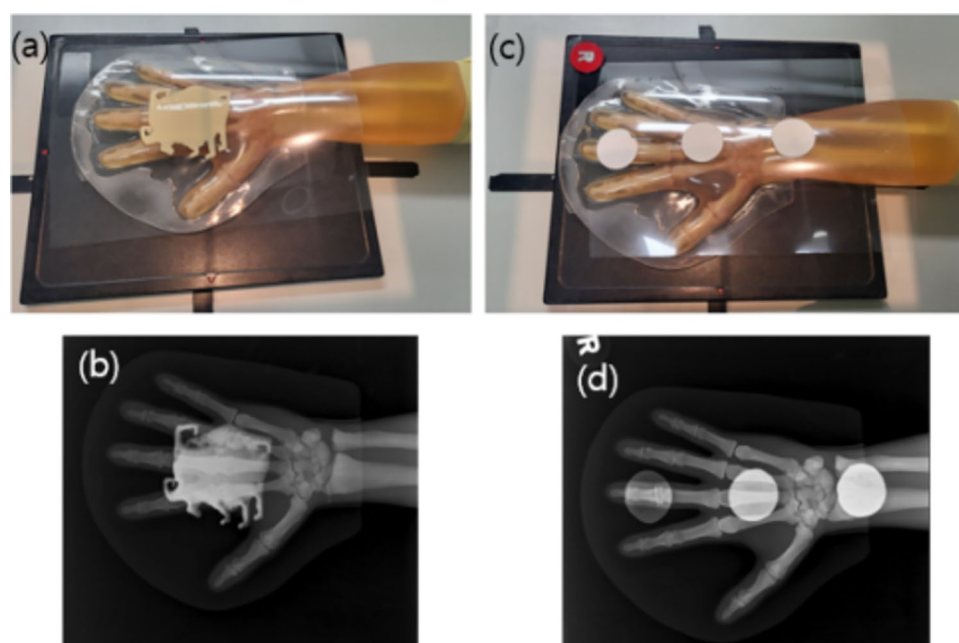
X-ray imaging (40 kVp, 5 mAs) of the radiation-reducing material at 25, 35, and 45 wt% and 1.0 mm thickness.
